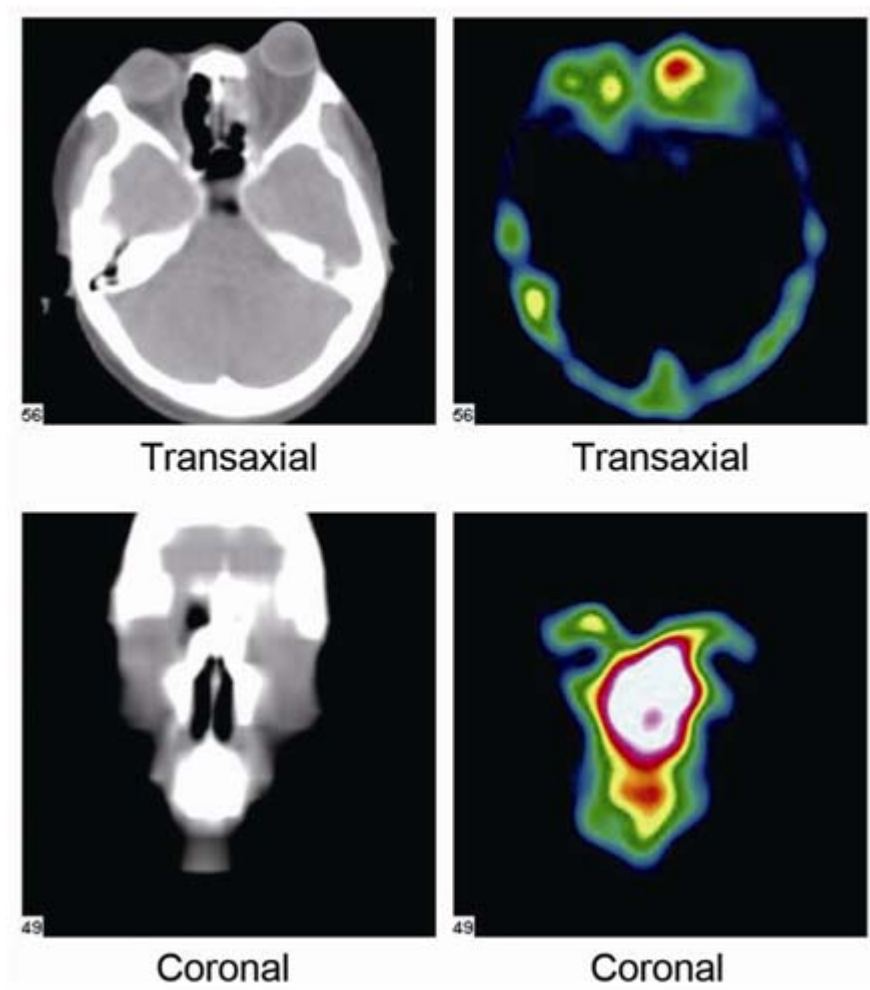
Orbital images from ^{99m}Tc -octreotide SPECT. A female patient aged 54 years suffered from left unilateral TAO of NOSPECS grade IV with an ADHOC CAS of 5. The two image frames were scanned with the same CT machine. The images in the second line on the left are ^{99m}Tc -octreotide SPECT. ^{99m}Tc -octreotide was denoted by a red color in the left postocular orbital region. The left occipital region and the right postocular orbital region presented reduced concentrations. The concentration was consistent with the corresponding ADHOC CAS.
